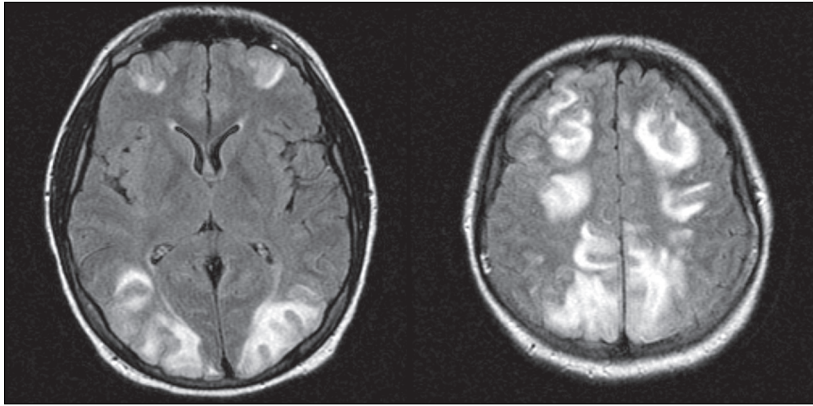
A 38-year-old woman with eclampsia who presented with seizures and coma. FLAIR images from MRI shows posterior reversible encephalopathy syndrome (white areas on the scans).
